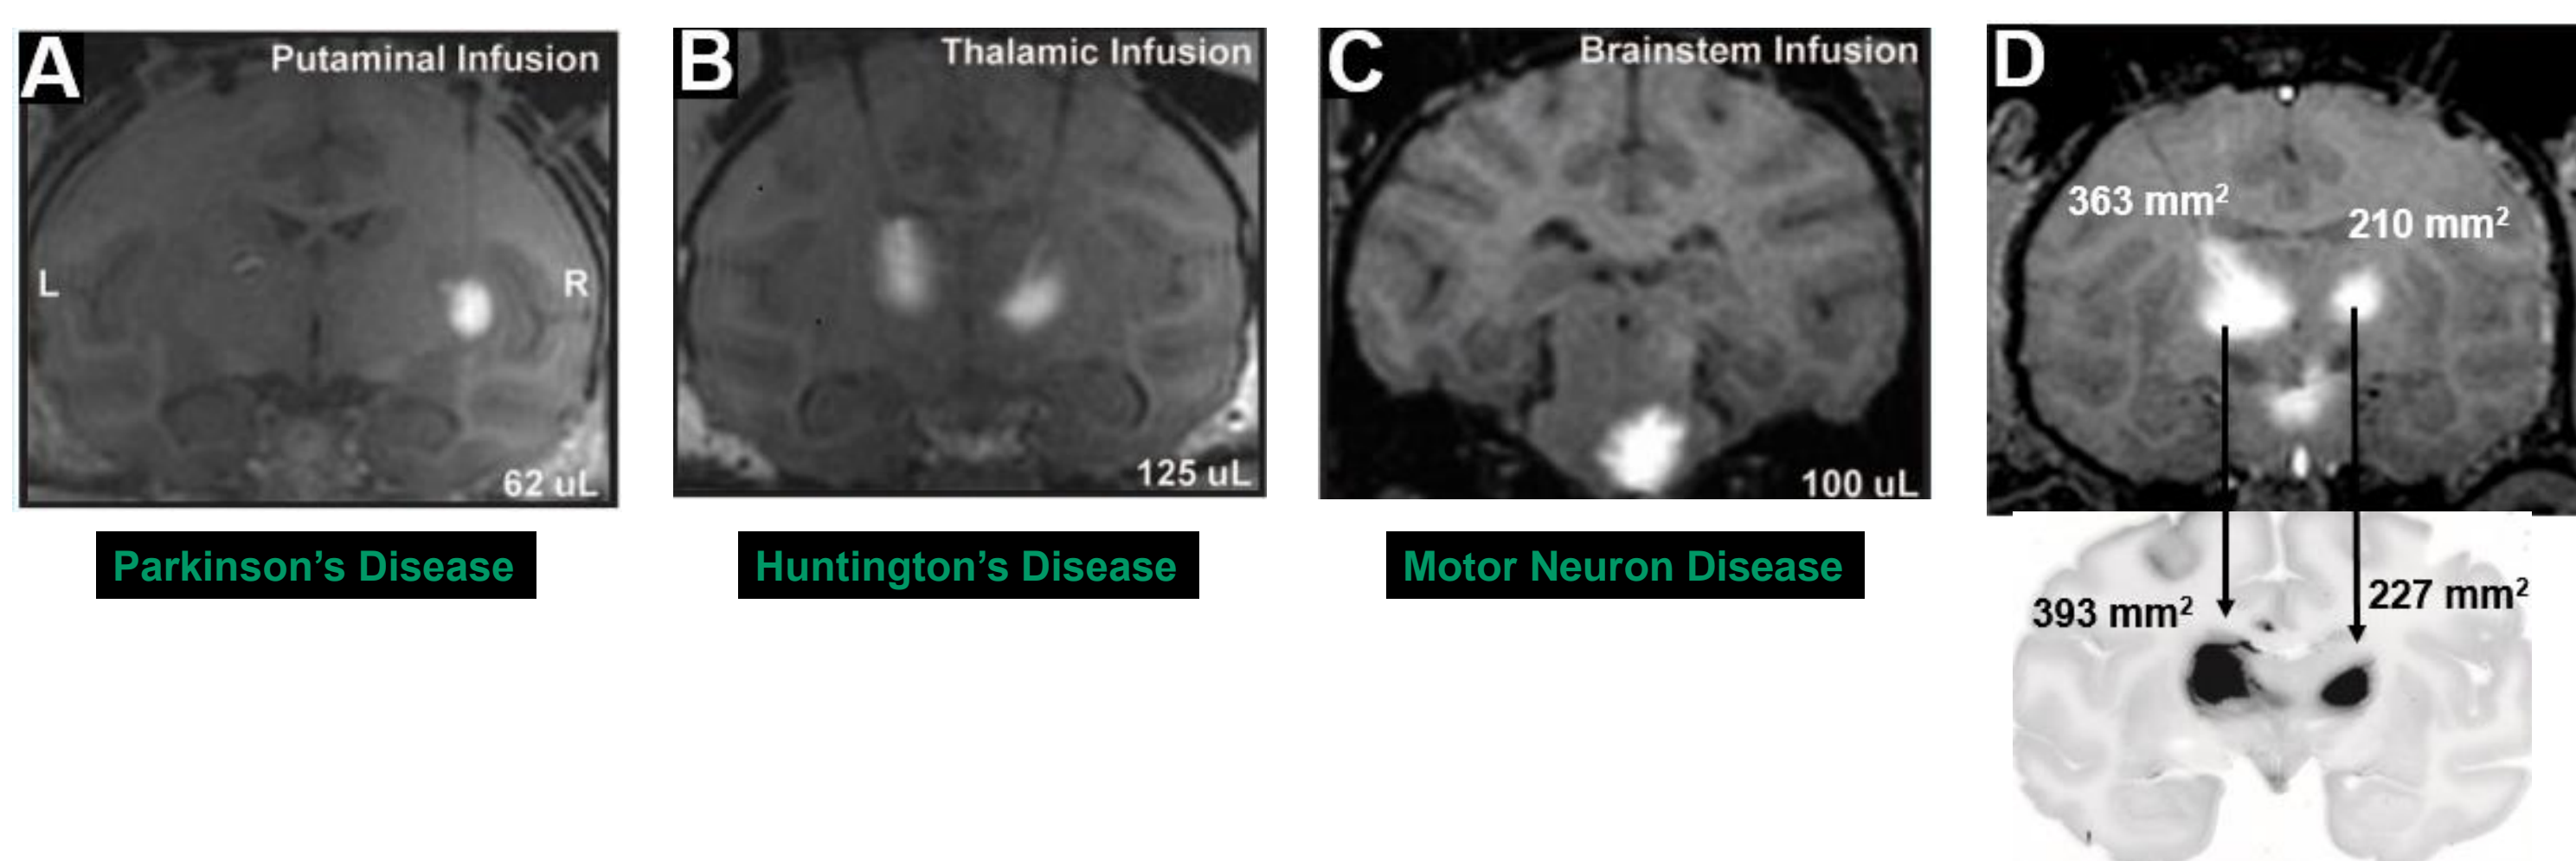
MRI Images Showing Real-Time Monitoring of Infusate Into Various Target Regions of Interest
